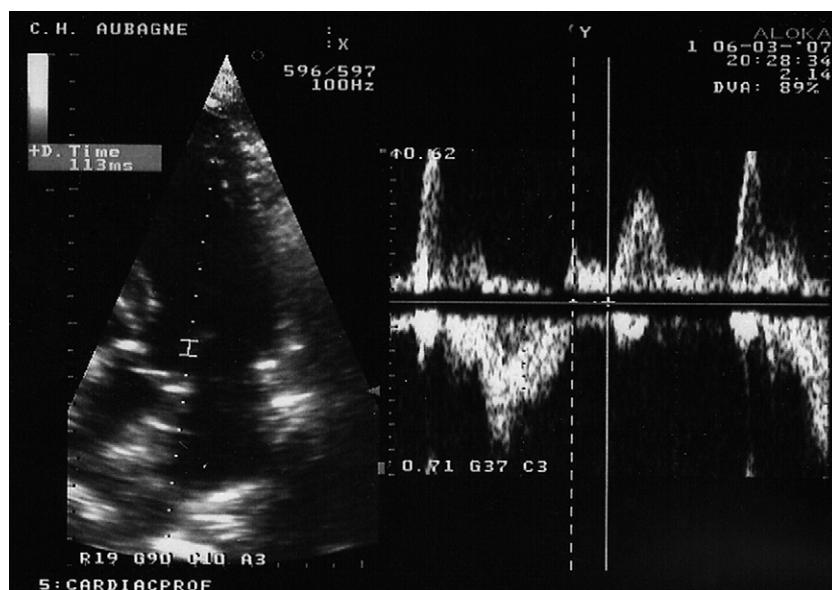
Measure of IVRT by pulsed Doppler, from the end of aortic flow (click of aortic closure) to the onset of mitral inflow, placing the pulsed wave Doppler sample volume between the mitral valve and the left ventricular outflow in a 5-chamber apical view.
